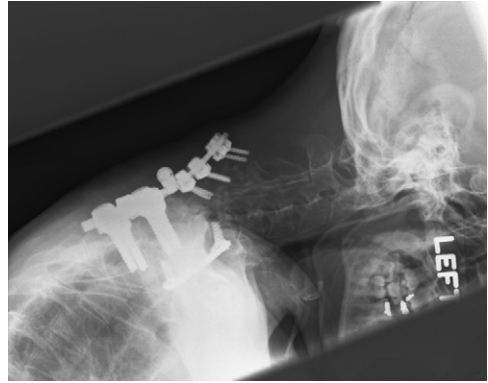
Two months after surgery, the patient presented to the clinic with worsening ability to look up. A lateral cervical spine radiograph was taken. Pullout of the screws at the CTJ was noted.
